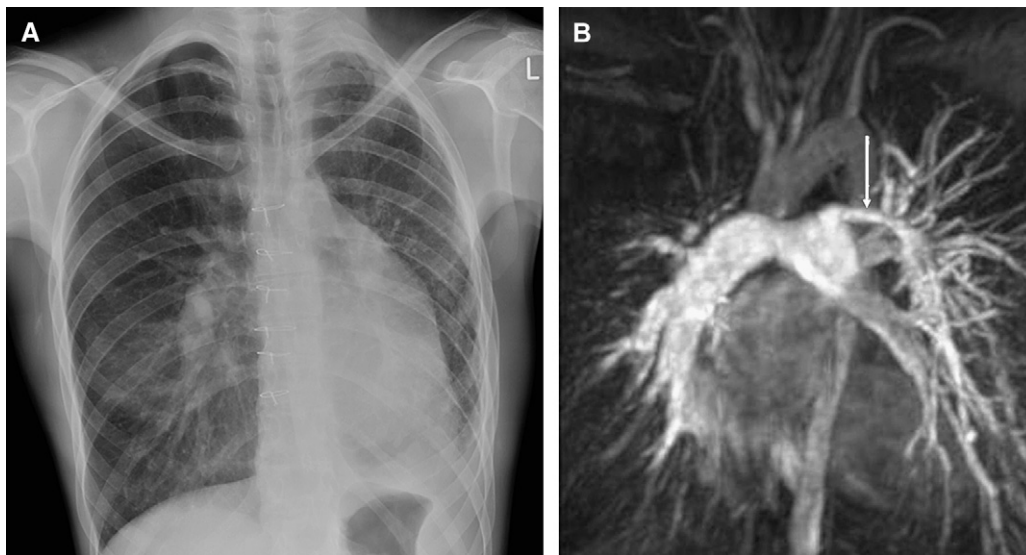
A 23-year-old woman with a history of left-sided congenital diaphragmatic hernia repair in early childhood. (A) Chest radiograph, showing a small left lung and leftward shift of the mediastinum. (B) MR pulmonary angiogram, showing a hypoplastic left pulmonary artery (arrow).
